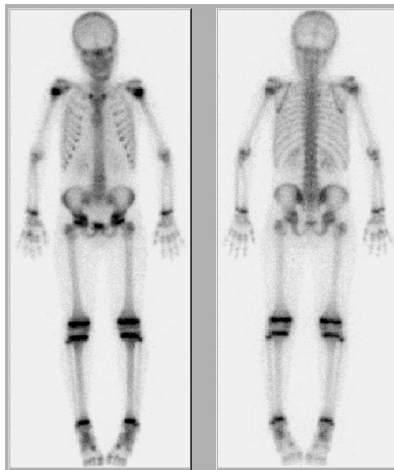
normal bone scintigraphy, performed with a gamma camera. We see the bone metabolism of a young patient (front and back view).
